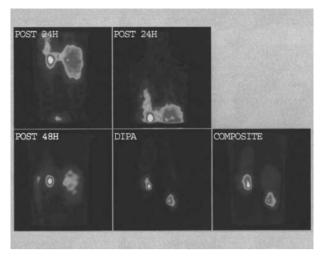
¹³¹I-meta-iodobenzylguanidine scintigram showing marked uptake at the single location corresponding to the left adrenal gland.
